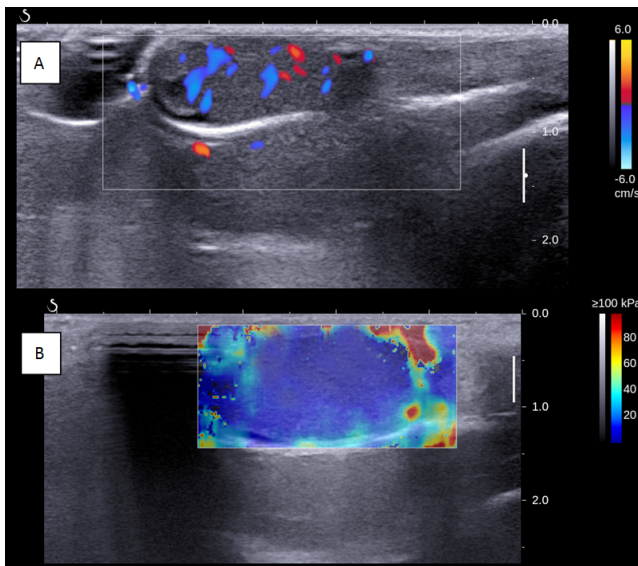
Ultrasonography of subcutaneously implanted VX₂ tumor in rabbits. (A) The lumps showed homogeneous low echo, and abundant blood flow signal could be seen in the interior and periphery; (B) SWE imaging, the tumor was relatively blue.
